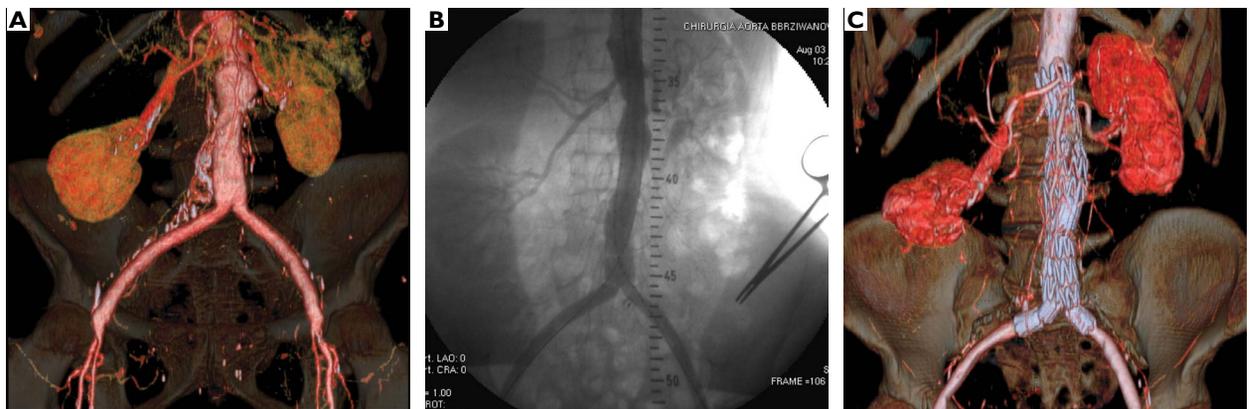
Patient 20. A volume rendering CT reconstruction shows pseudoaneurysm of proximal anastomosis (A). Intraoperative control angiogram after implantation of bifurcated Zenith stent-graft (B). A volume rendering CT reconstruction performed 12 months after the secondary procedure (C)
